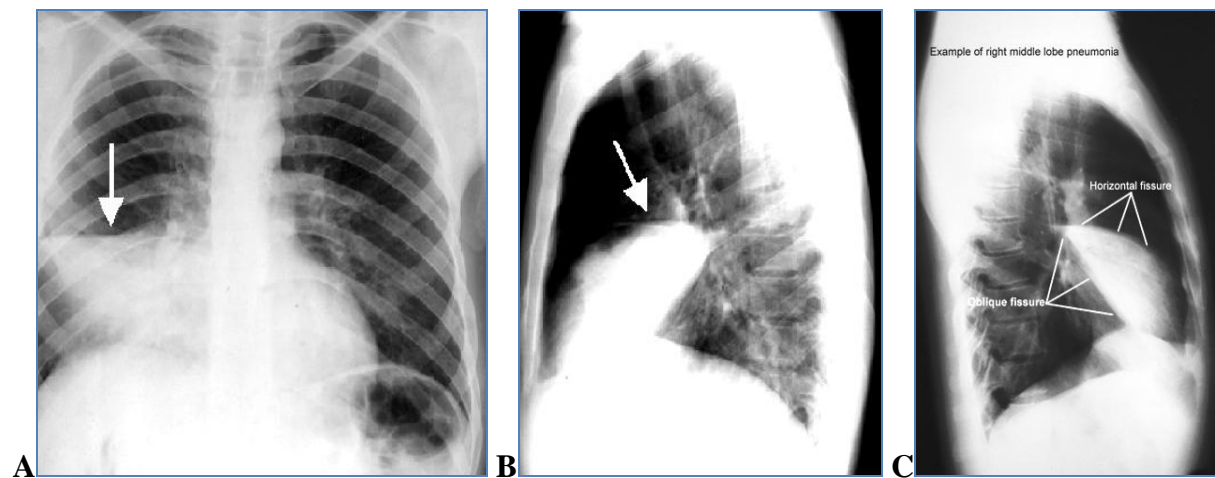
Pneumonia. (A) PA and (B to C) lateral projections of right middle lobe consolidation. Frontal chest radiograph demonstrates obliteration of the right borders of the heart. Patchy, diffuse air-space acute lobar consolidation, infiltrate with a focal area of consolidation in the right middle lobe (arrow)
